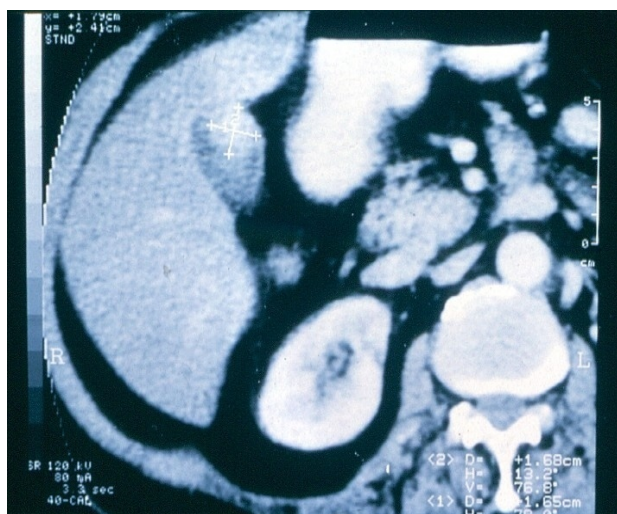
Image of polypoid lesion of the fundus of the gallbladder on CT scan examination.
